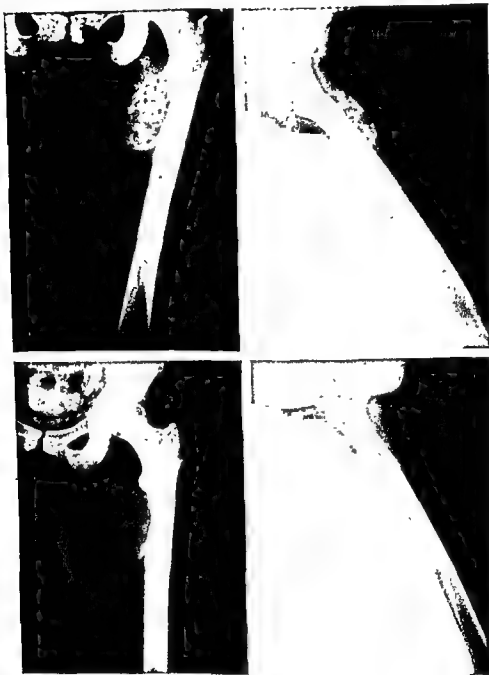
Giant cell tumor atypical because of location. Preoperative roentgenograms above, postoperative below. (*Am. J. Roentgenol.* 47:544, 1942.)
